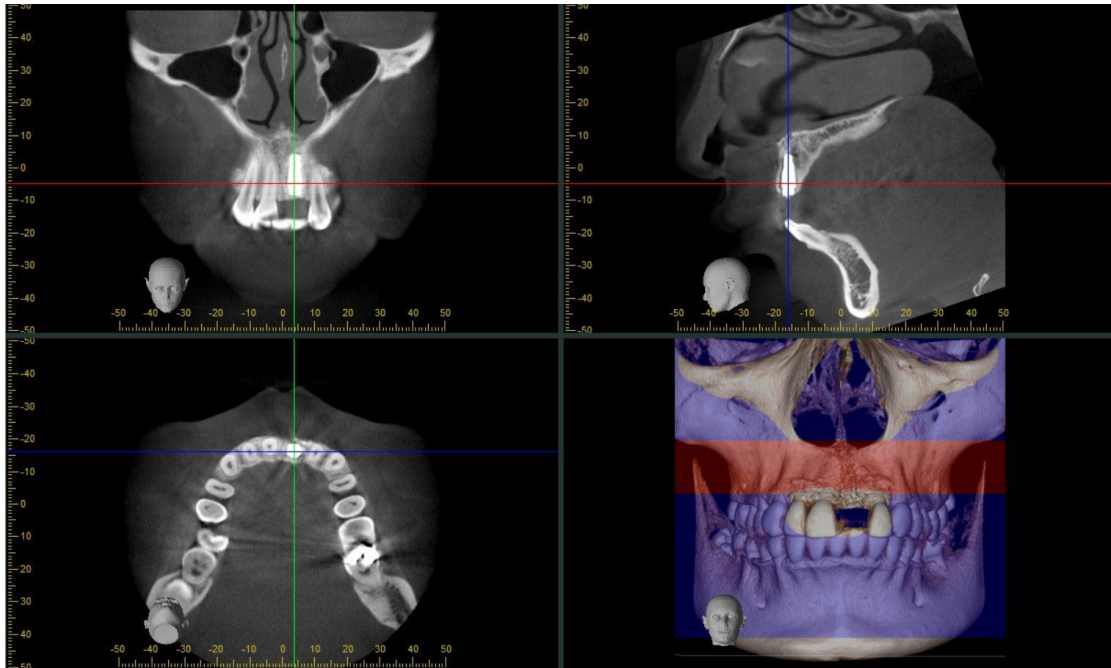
shows radiographic image shows reference line in 3 views: coronal, sagittal, and axial.
